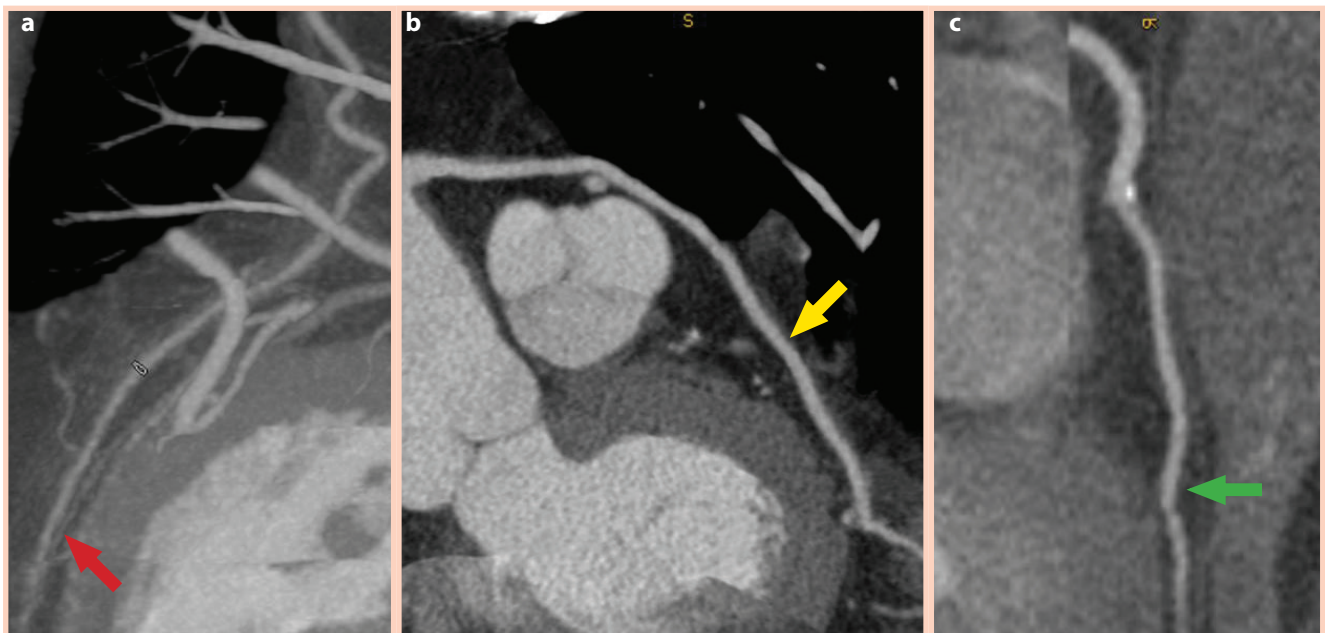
CT angiography of adequately placed grafts, LIMA on LAD (a, red arrow), LRA on OM1 (b, yellow arrow) and con Rd1 (c, green arrow).
